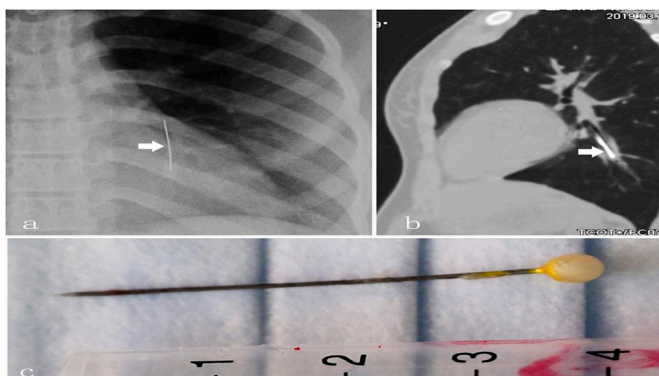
a: A needle-shaped high-density shadow in the field of LLL was shown in the chest X-ray, partially overlapping with the heart shadow, as indicated by the white arrow. Fig. 1b: The needle-shaped foreign body was located in the distal endobronchial lumen of the LLL in the sagittal position of the chest CT, as indicated by the white arrow. Fig. 1c: The metallic needle approximately 4 cm in length removed from the airway.
